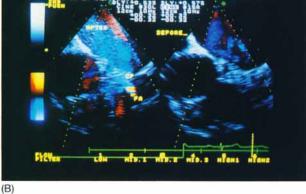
(A) Transesophageal echocardiographic assessment of proximal coronary arteries after contrast enhancement. After contrast injection (left), prominent flow signals fill the lumen of the left main coronary artery and the proximal left anterior descending coronary vessel, which shows hardly any flow signals at baseline (right). (B) Transesophageal echocardiographic assessment of proximal coronary arteries after contrast enhancement. At baseline (right), virtually no flow signals are noted in the left main coronary artery. After contrast injection (left), prominent flow signals not only completely fill the lumen but also opacify an additional segment of the proximal left anterior descending coronary vessel that was not visualized at baseline. In addition, flow aliasing is noted more distally, and its site corresponds to an area of severe stenosis in the left anterior descending artery on the coronary angiogram. CF = the origin of the circumflex vessel. Reproduced from Ref. No. 25 with permission.
